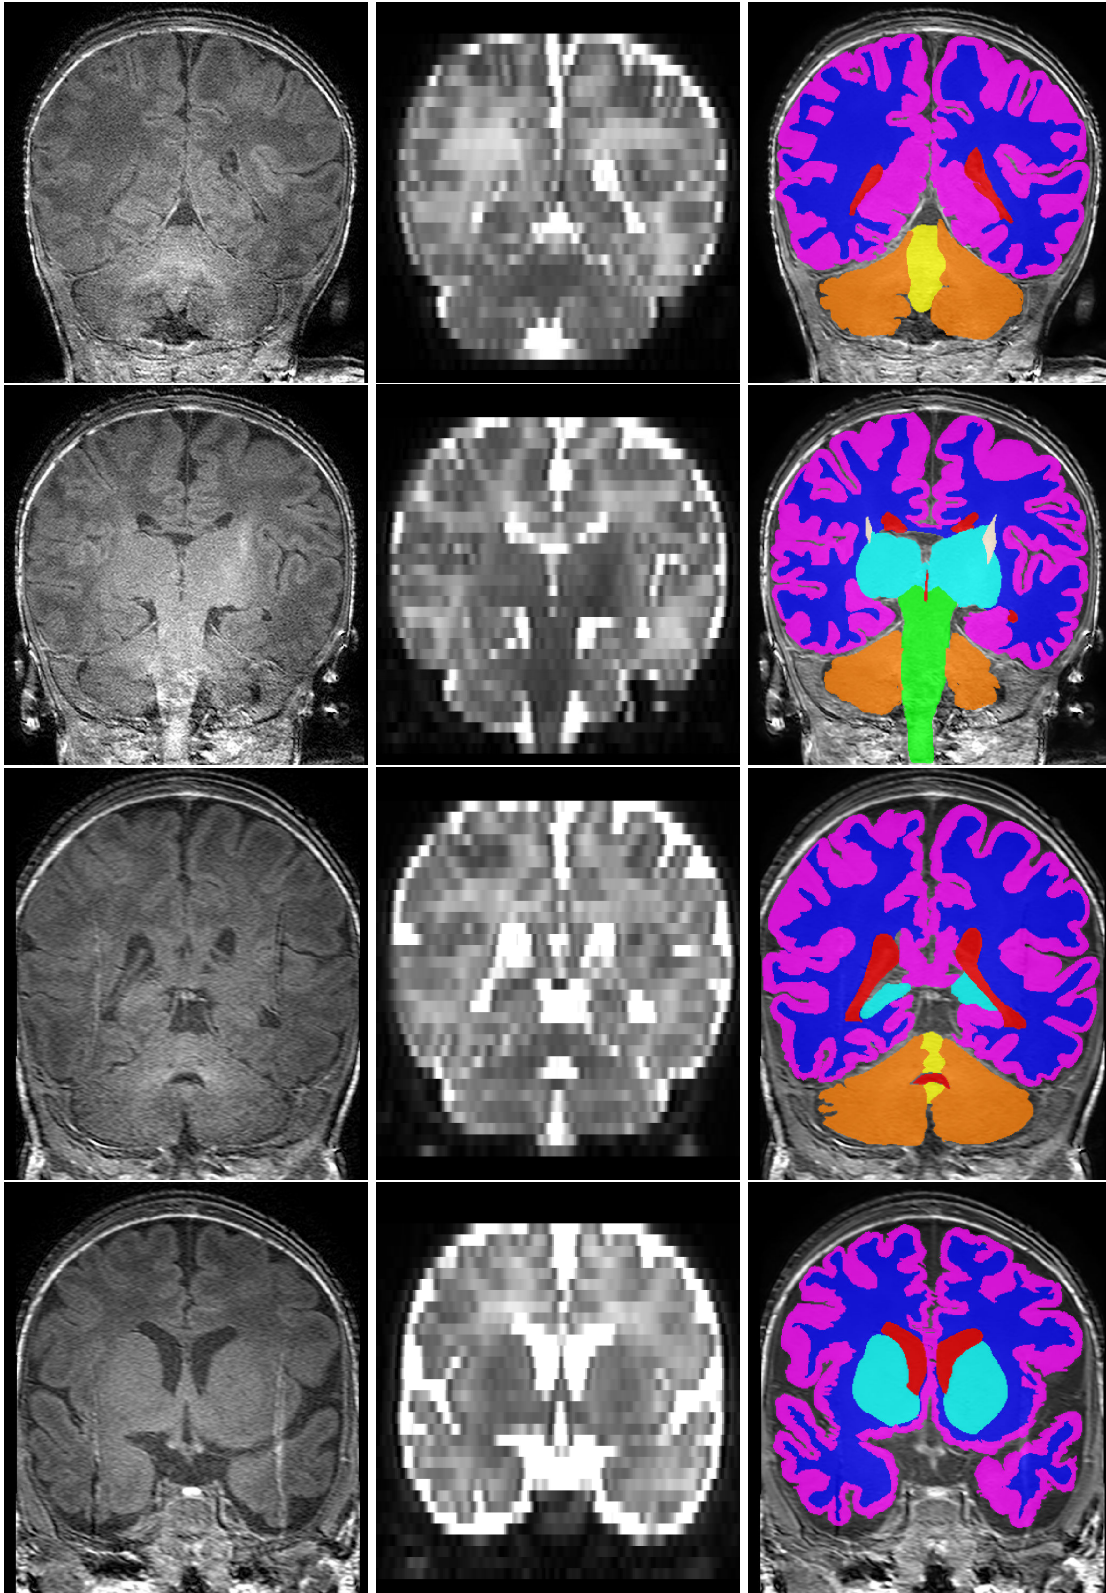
Two subjects from the ANR MAIA dataset. Left to right: T1w MR image, T2w MR image and the manual segmentation (ventricular system in red, basal nuclei in cyan, cerebellar hemispheres in orange, vermis in yellow, brainstem in green, cortical grey matter in magenta, myelinated white matter in beige and unmyelinated white matter in blue).
